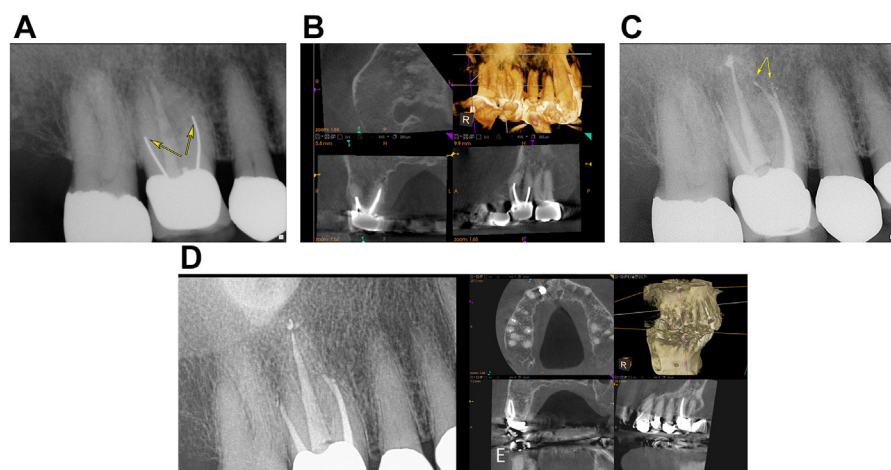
Example of a patient with odontogenic sinusitis (ODS) due to a molar with apical periodontitis after prior RCT. This patient had right-sided sinusitis symptoms and underwent multiple sinus surgeries over years, and had not been referred to an endodontist to evaluate the prior RCT. (A) Preoperative radiograph showing an incomplete RCT with silver points partially filling the buccal canals (yellow arrows), and this was a likely source of recurrent or ongoing endodontic disease. (B) Preoperative CBCT showed right maxillary sinus opacification consistent with ODS (confirmed purulence endoscopically). (C) Periapical radiograph immediately following RCT, showing complete filling of the root canal spaces. The two yellow arrows show a filled apical bifurcating root canal terminus that was previously not sealed with a single "floating" silver point. (D) Periapical radiograph 6 years post-treatment showing a stable complete RCT, and patient was asymptomatic. (E) Six-year follow-up CBCT showing successful RCT and complete osseous integrity of the periapical region, but persistent maxillary sinus opacification. The patient was referred back to the otolaryngologist for sinusitis management.
